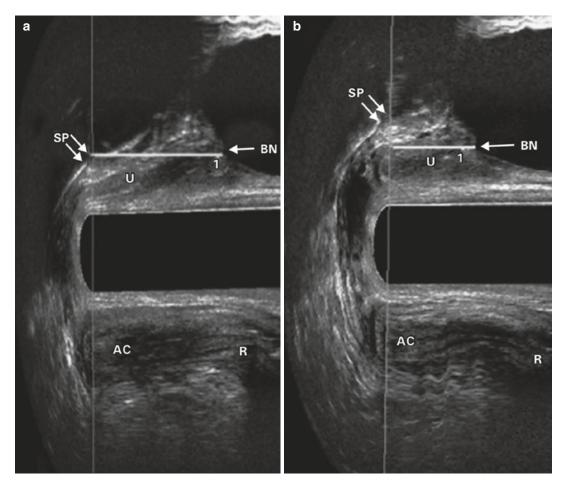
Mean decrease in the perineum and decrease of the bladder was 0.6 cm and 0.5 cm above the pubic symphysis, respectively. (a) evaluation of the descending of the perineum by endovaginal ultrasound. (b) decrease in the perineum and bladder above the pubic symphysis. SP = pubic symphysis; BN = bladder neck; U = urethra; R=right
